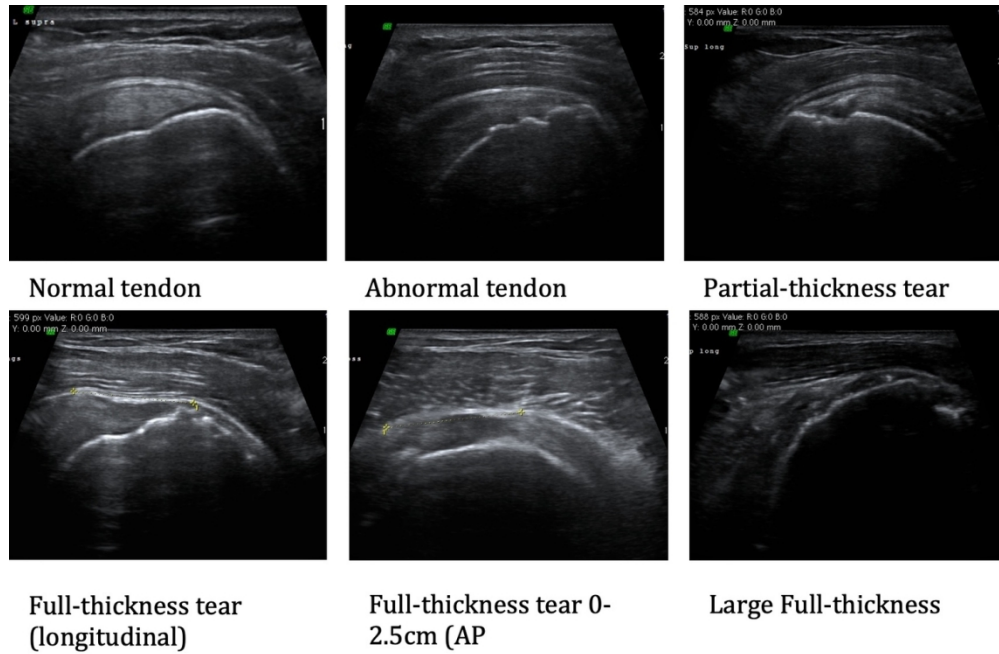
Ultrasound images
